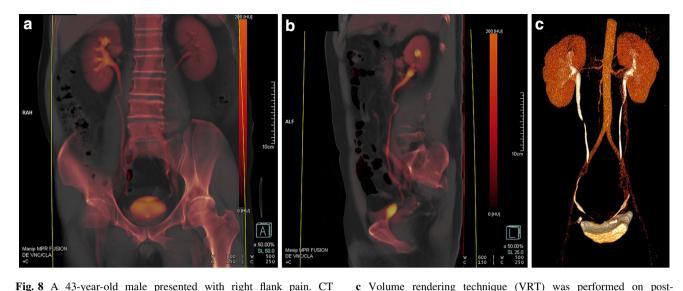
A 43-year-old male presented with right flank pain. CT urography was performed and revealed an obstructing right distal ureteric calculus with resultant right hydroureteronephrosis. Dynamic MPR evaluation was performed on 'iodine overlay' images with manipulation of slice thickness, achieving overview 'big picture' images a, b which are excellent for explaining findings to patients.
